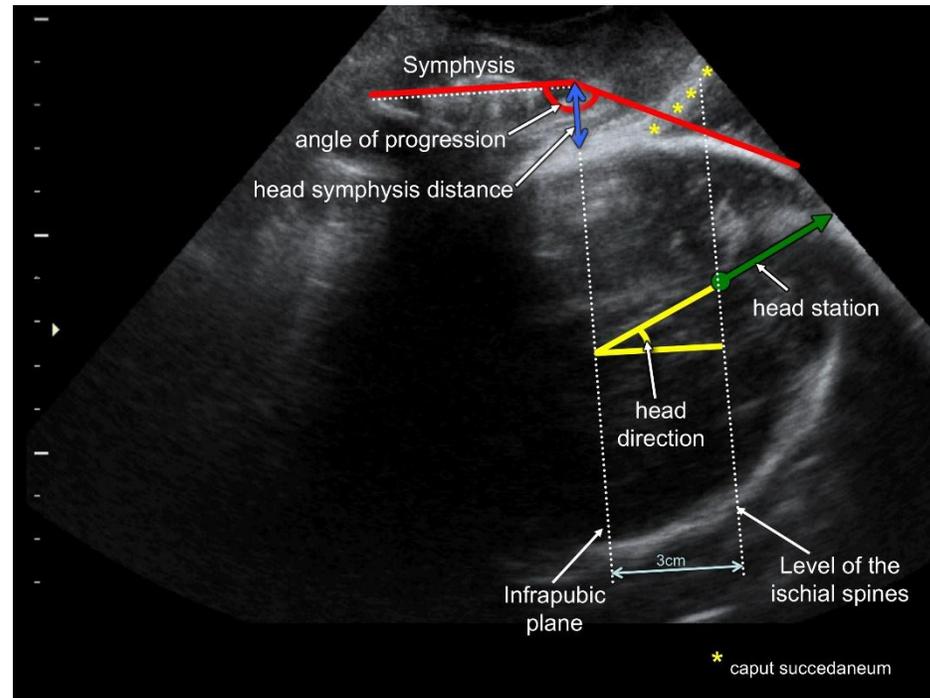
The transperineal ultrasound head station should be measured along the line indicating head direction. The angle of progression (AoP), the head-symphysis distance, and, as reference planes, the measurable infrapubic plane and the inferred ischial plane, are also shown (modified from 32)
